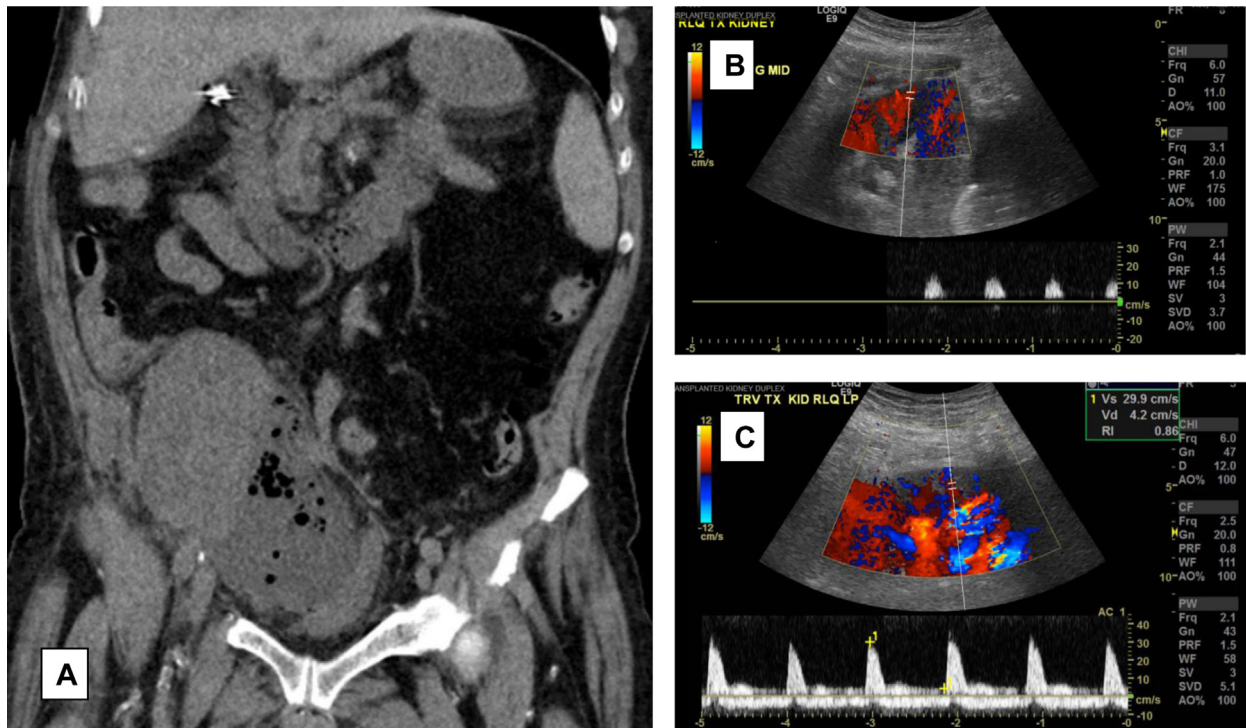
(A) Noncontrast computed tomography of the abdomen and pelvis shows 14 cm of peritransplant subcapsular fluid and gas collection with local mass effect. (B) Renal duplex ultrasound before drain of the subcapsular collection reveals minimal perfusion in the mid and upper poles with no end-diastolic flow. (C) Renal duplex following drain of the subcapsular collection shows blood flow. Color Doppler shows arterial flow in red (flow toward transducer) and venous flow in blue (away from transducer). Different shades of red and blue depict different flow rates.
